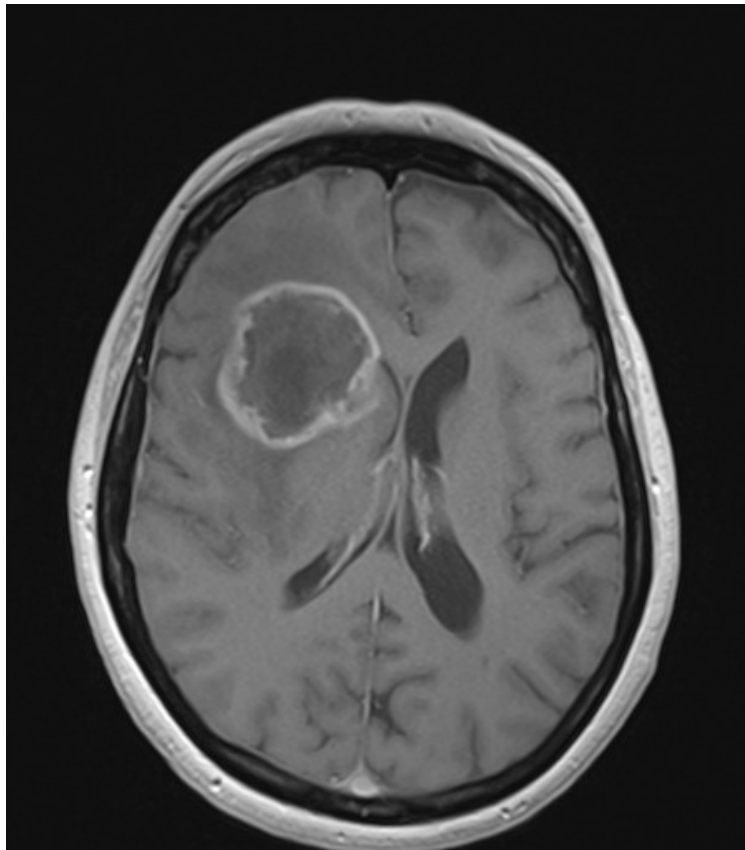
A representative post-gadolinium axial T1-weighted MR image of an IDH-wildtype glioblastoma with subventricular zone contact and a large necrotic core region.
